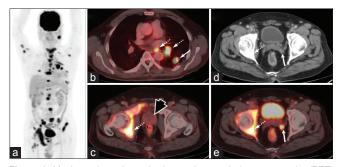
Maximum intensity projection positron emission tomography (PET) image showing multiple focal areas of 18F-Fluorodeoxyglucose (18F-FDG) uptake in the head and neck, thorax, abdomen and pelvis (a). Contrast enhanced PET/ computed tomography image of the thorax showed a nodular 18F-FDG avid lesion (SUVmax-5.6) in left lung upper lobe, measuring 1.7 cm × 1.5 cm and showing pleural tagging (b, arrow), along with multiple 18F-FDG avid mediastinal nodes (b, broken arrows). Prostate gland was normal in size with no definite focal 18F-FDG uptake or space occupying lesion (c, arrowhead). Also noted was an enhancing space occupying lesion (d, e, bold arrow) measuring 1.3 cm × 0.8 cm in size in left seminal vesicle showing increased 18F-FDG uptake (SUVmax-5.1). Also noted were multiple 18F-FDG avid skeletal lesions (c-e, broken arrows)
